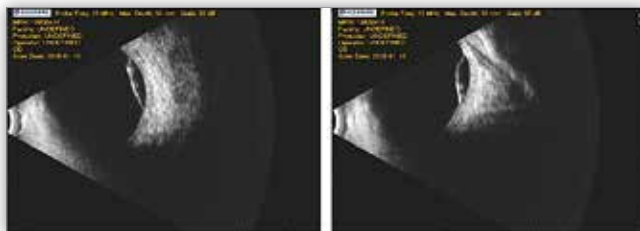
Ultrasound scan of both eyes performed one day after delivery. A significant detachment of sensory retina is visible bilaterally in the posterior pole.
